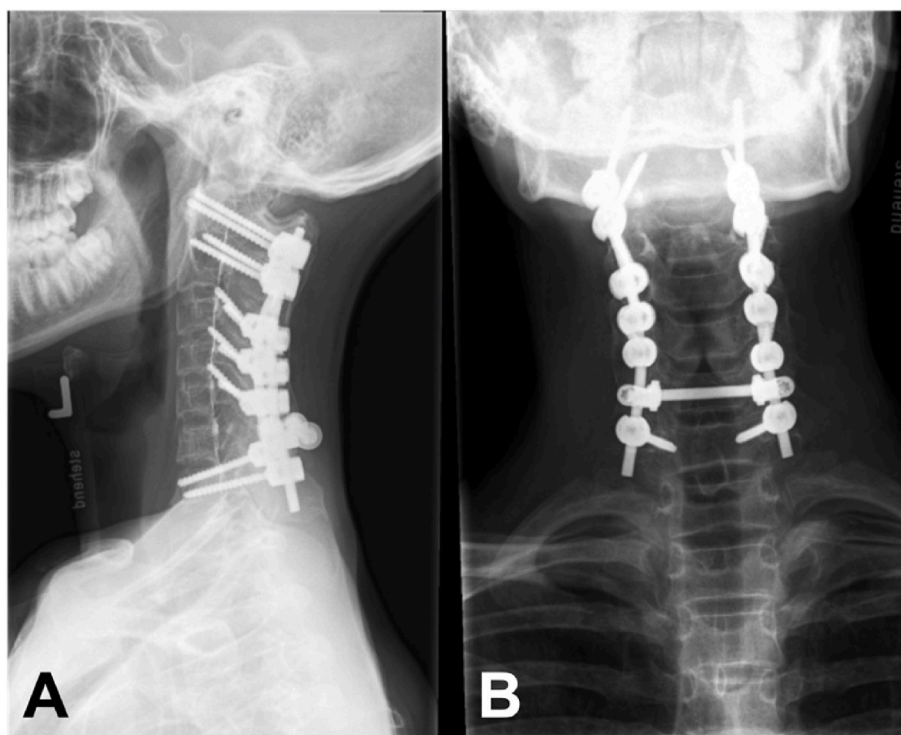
Sitting ap and lateral plain radiographs two years after posterior C2-7 stabilization.
